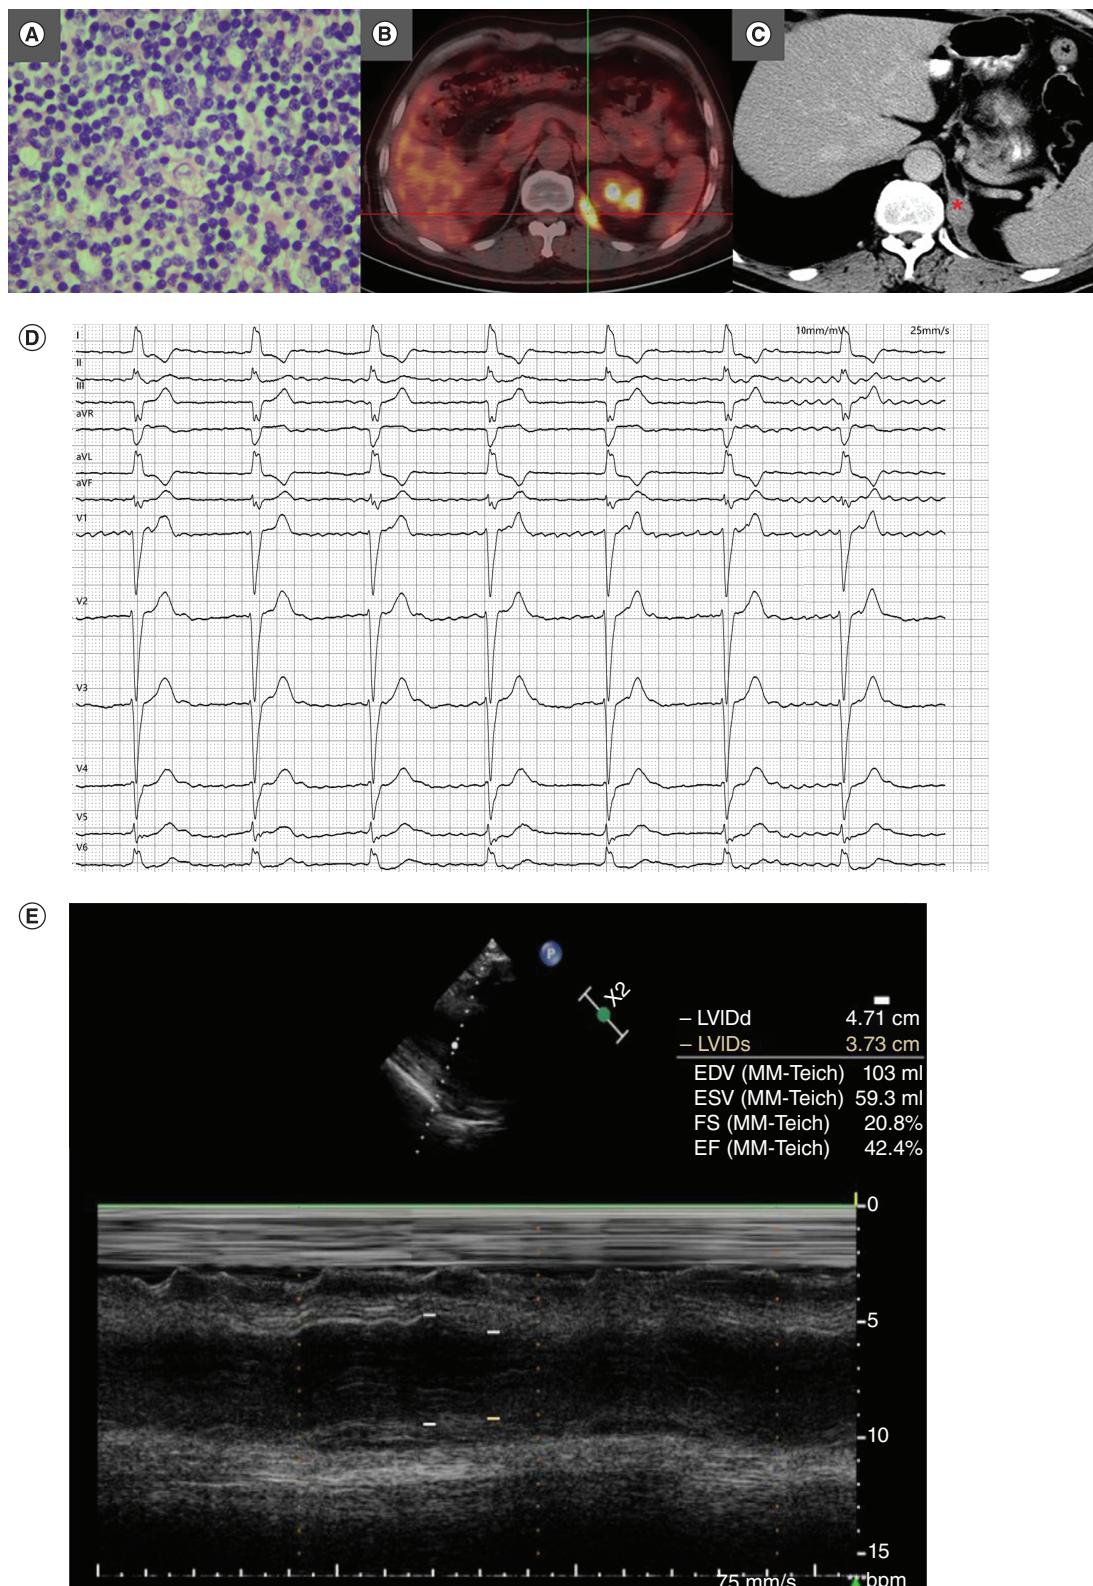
Characteristic of patient 1. (A) Pathological diagnosis of case 1 was WHO type B1 thymoma. (B) Metastasis of pleura and left diaphragmatic angle. (C) Enlarged mass in left diaphragmatic angle. (D) Echocardiogram examination suggested third-degree atrioventricular block. (E) Echocardiogram showed acute heart failure with a left ventricular ejection fraction less than 50%.
